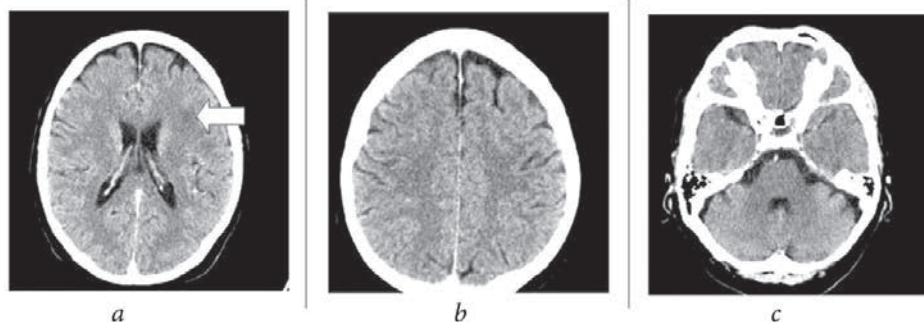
Computed tomography of the brain done 15 years post trauma: *a* — arrow shows a hypodense subcortical left frontal lesion; *b* — asymmetrical cortical atrophy more pronounced on the left; *c* — right anterior temporal lobe and cerebellar atrophy.
